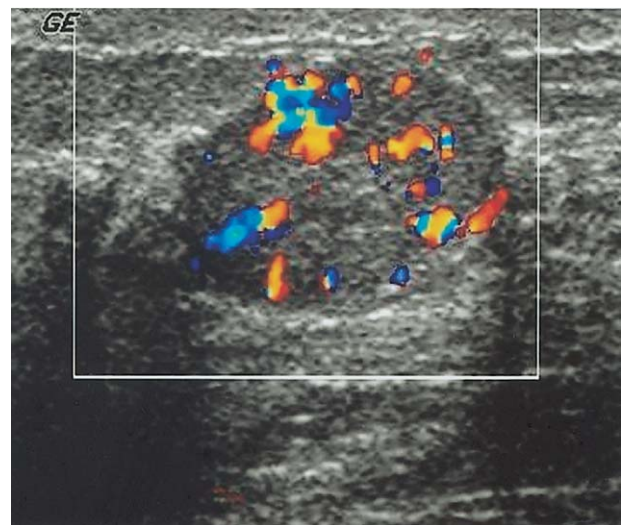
An isoechoic nodular lesion with smooth border, distal enhancement and prominent intralesional color flow signals at color Doppler study, which was an intraductal papilloma.
